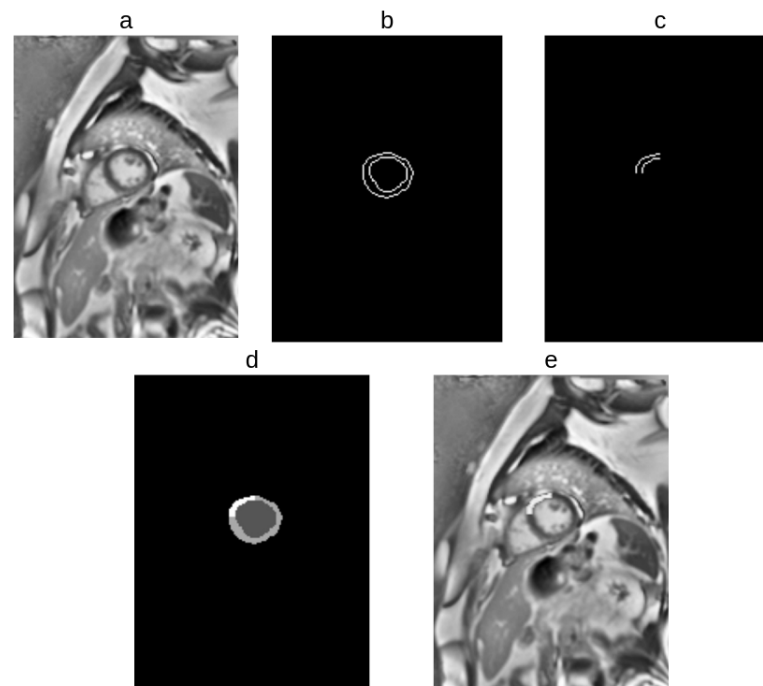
Summary of the data augmentation method for a case of TMI: (a) original DE MRI; (b) segmentation of myocardial contours; (c) selection of working quadrant; (d) MI ROI generation; (e) MI generation in DE MRI.
